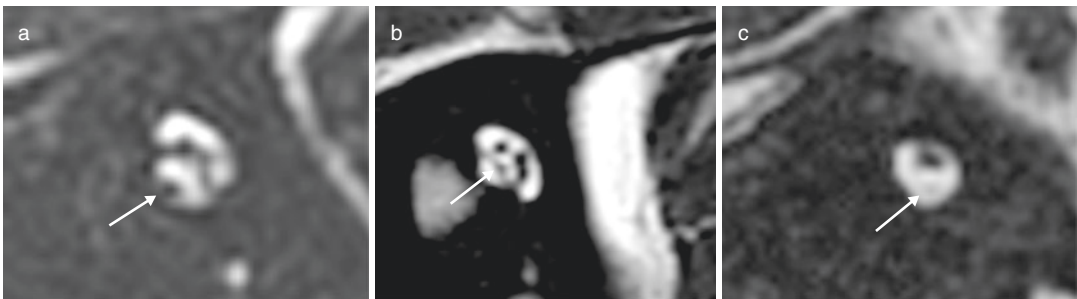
Cochlear nerve. Cochlear nerve is evaluated on axial and sagittal oblique T2-weighted MRI images. And it is classified as normal (a), hypoplastic (b), and aplastic (c), according to its size relative to the ipsilateral facial
